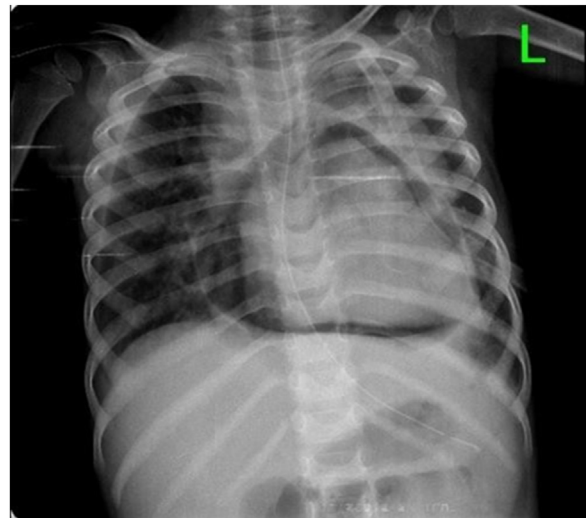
Chest X-ray taken 2 days later showing relatively decreased air within the pericardium.
